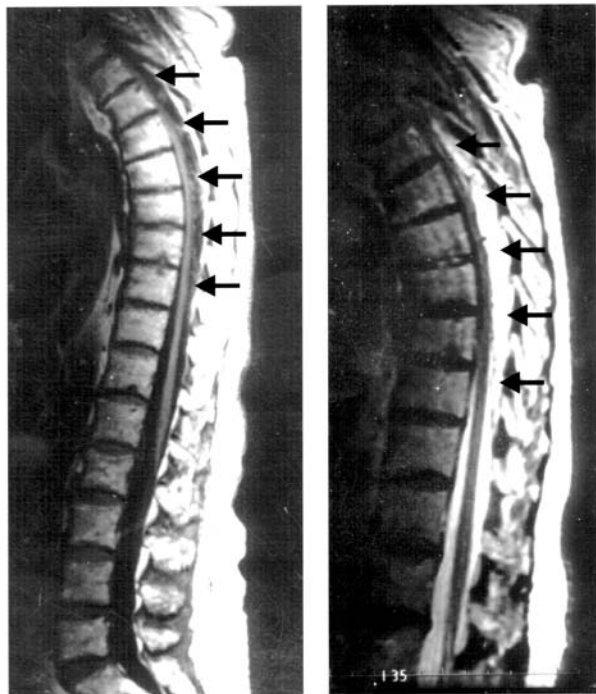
Sagittal magnetic resonance images of the thoracolumbar spine. A large complex epidural hematoma extending from ~ T3 to T10/11 is seen with hypo- and isodense signal characteristics on a T1-weighted image (left; arrows) and hyperintense signal characteristics on a T2-weighted image (right; arrows). At the centre of the hematoma, the spinal cord abuts the posterior aspect of the thoracic vertebral bodies (left). No signal abnormalities of the cord itself are seen.
